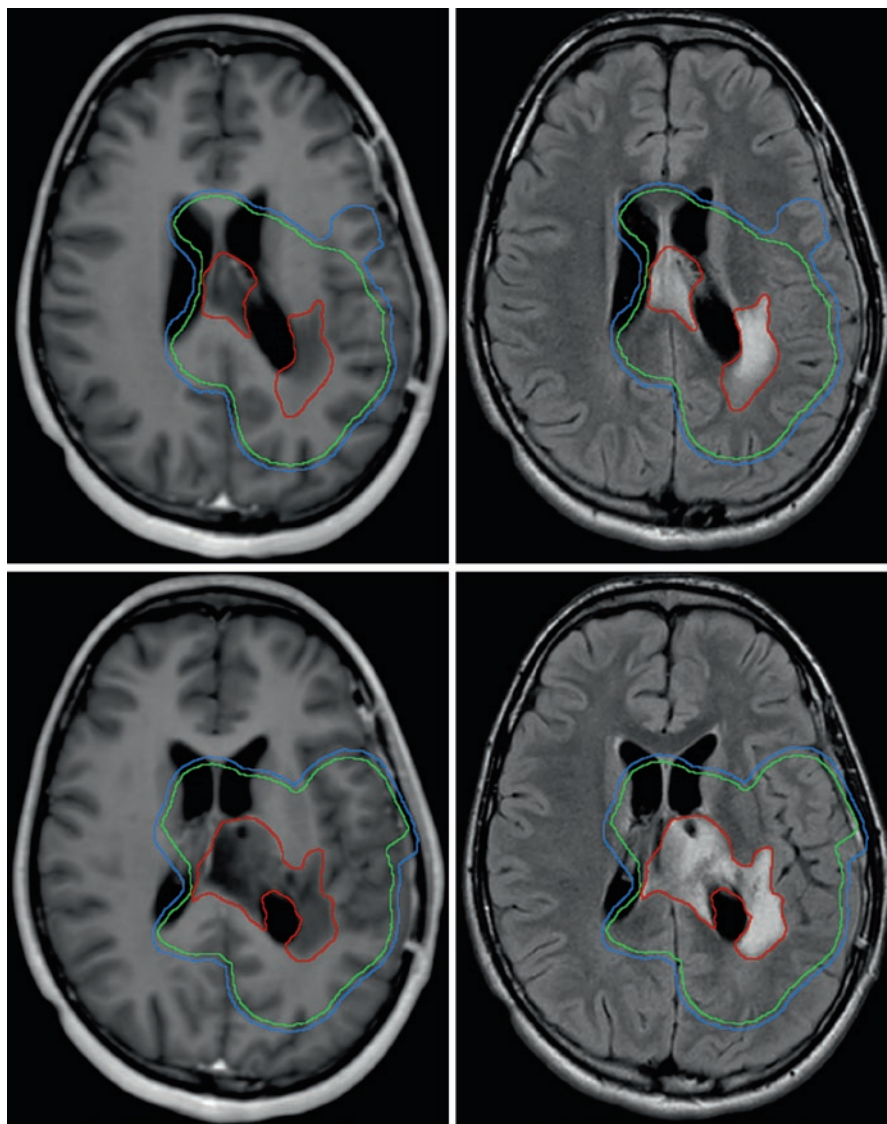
High-grade glioma case. Axial T1 post-contrast MRI is shown on the left and axial T2/FLAIR images on the right. The patient has a large left thalamic glioblastoma status-post subtotal resection. Red = GTV1 which includes both the enhancing component and T2/FLAIR signal. Pink = GTV2 which includes the residual enhancing tumor in addition to the surgical cavity. Green = CTV (GTV1 + 1.5 cm). Blue = PTV (CTV + 3 mm). The GTV1 was felt to be small enough that GTV 2 = GTV 1 and the entire target could be safely treated to 59.4 Gy. Yellow = optic nerves and chiasm. Note that part of the chiasm is within the PTV, but the normal tissue tolerance of this structure should be respected and a “cold” spot allowed within the target to achieve this
